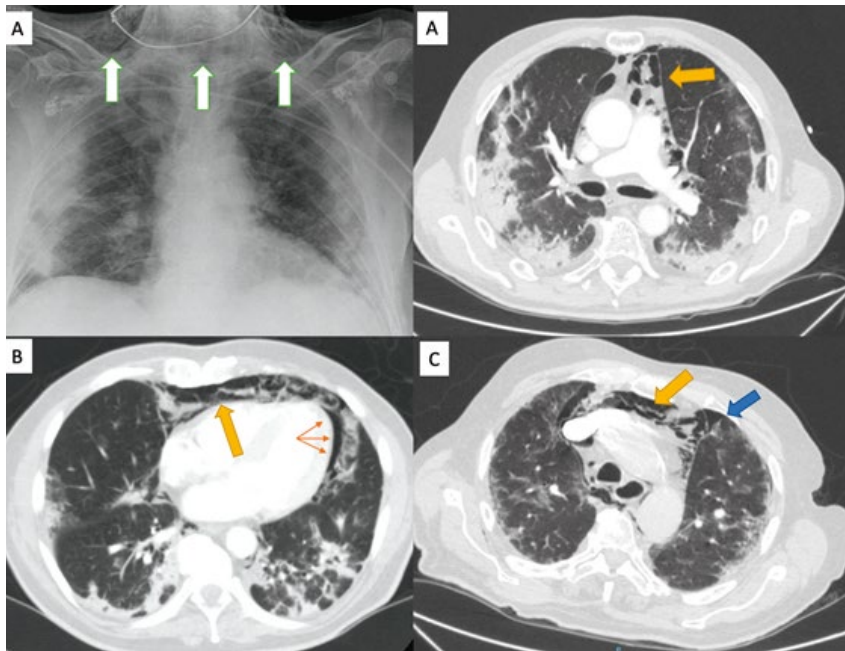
Chest CT scans of the patients presented where the alterations described in the text are observed. White arrows: subcutaneous emphysema; yellow arrows: pneumomediastinum; red arrows: pneumopericardium; blue arrow: pneumothorax
